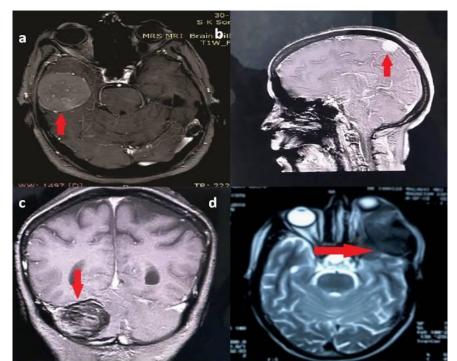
MRI brain showing extraaxial contrast enhancing lesion at a) frontal convexity, b) parasagittal and c) cerebellar location. d) Shows Atypical Meningioma in sphenoid wing extending to orbit
